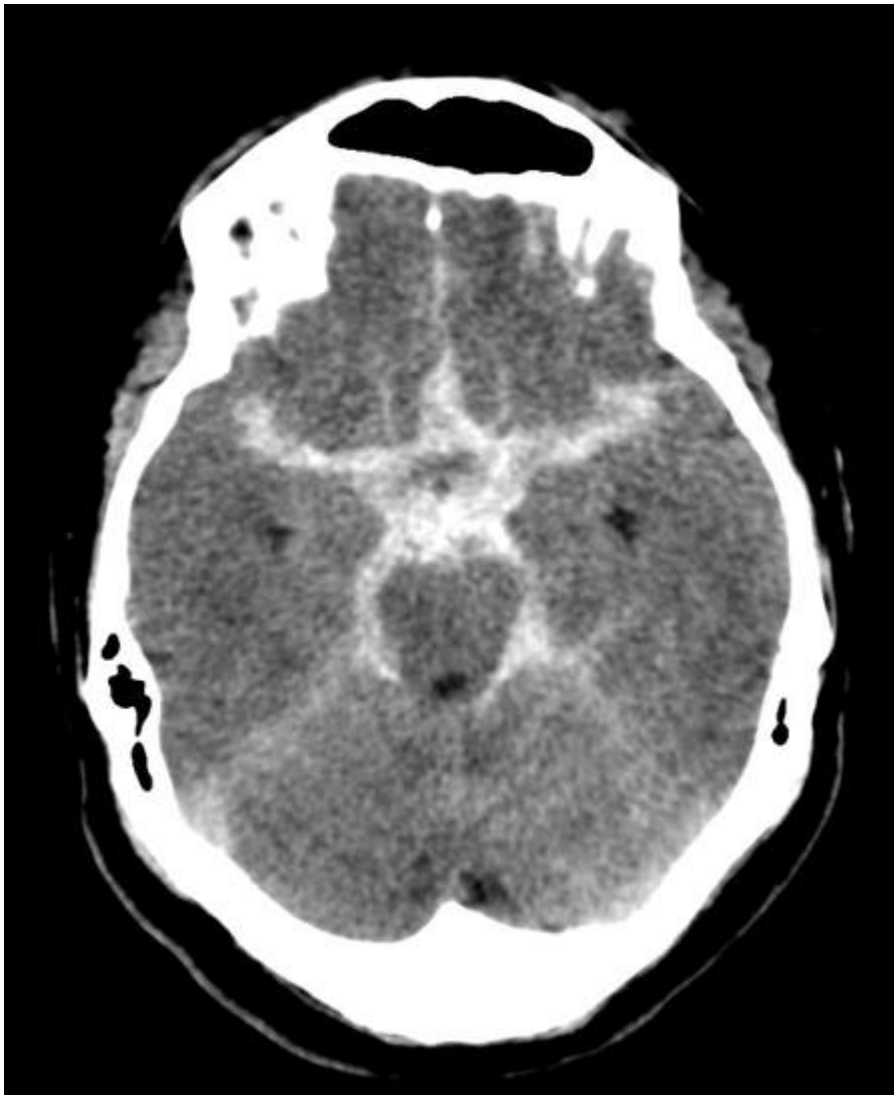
CT demonstrating diffuse Subarachnoid hemorrhage in all basal cisterns, bilateral sylvian fissure and interhemispheric fissure. Case courtesy of David Puyó, Radiopaedia.org, rID: 22377
